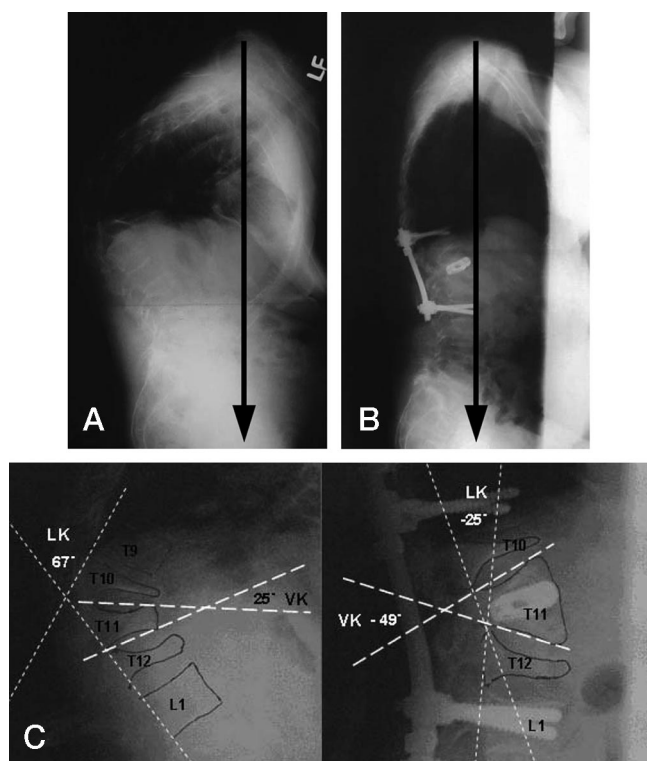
A, This 71-year-old woman presented with a severe thoracolumbar kyphosis and markedly positive sagittal balance as a result of wedge fractures at T10, T11, and T12. B, Standing radiographs obtained at 2 years postoperatively showed ALO at T11 to restore a normal sagittal alignment. C, The local kyphosis (LK) was corrected from 67° to -25°. The vertebral kyphosis (VK) was corrected from 25° to -49°.
